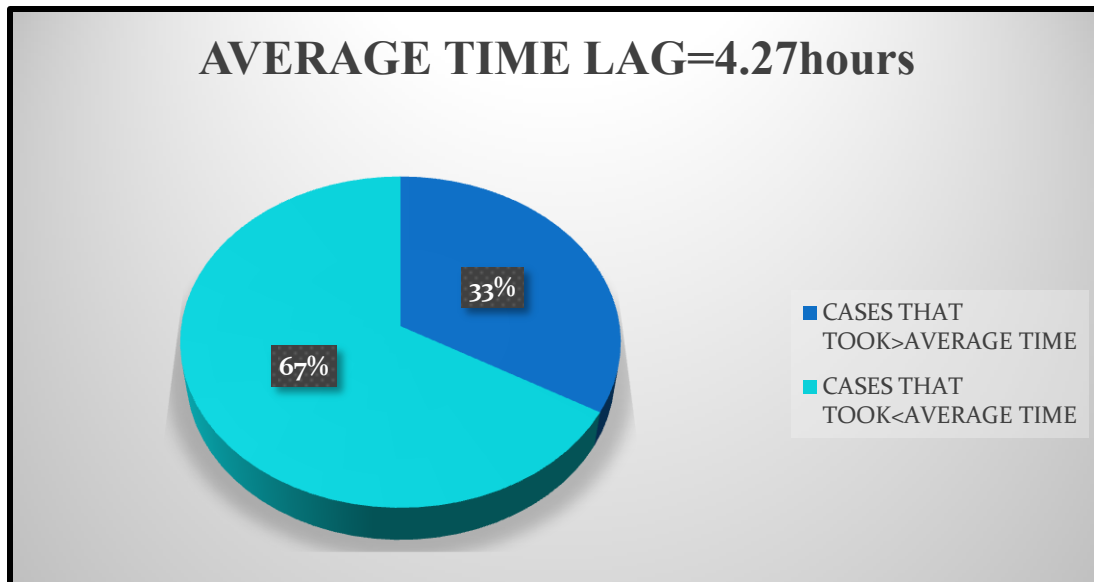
TIME LAPSE BETWEEN THE X-RAY TAKING TIME AND THE TIME AT WHICH THE RADIOLOGIST DID THE REPORTING
